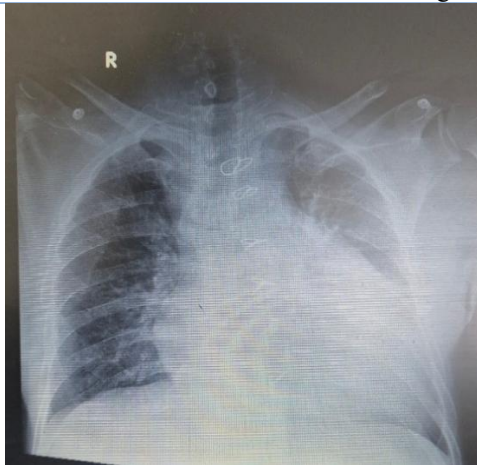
Chest X-ray AP view of patient on admission: cardiac silhouette is enlarged and sternotomy sutures noted.
